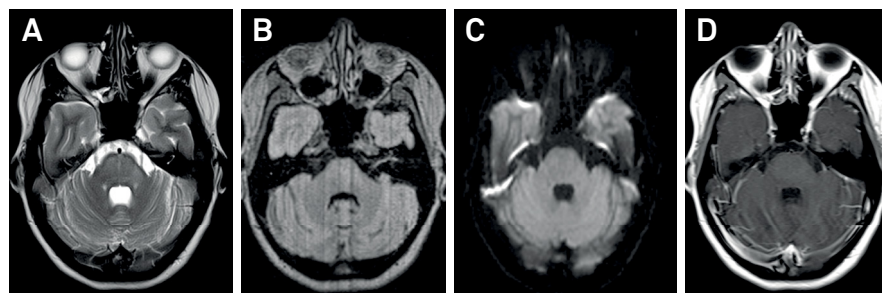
Brain MRI after treatment. Axial T2 weighted (A), FLAIR (B) and DWI (C) sequences demonstrate almost complete resolution of the brainstem lesion. Axial T2 weighted image shows discrete hyperintense lesion (A) without gadolinium enhancement (D).
